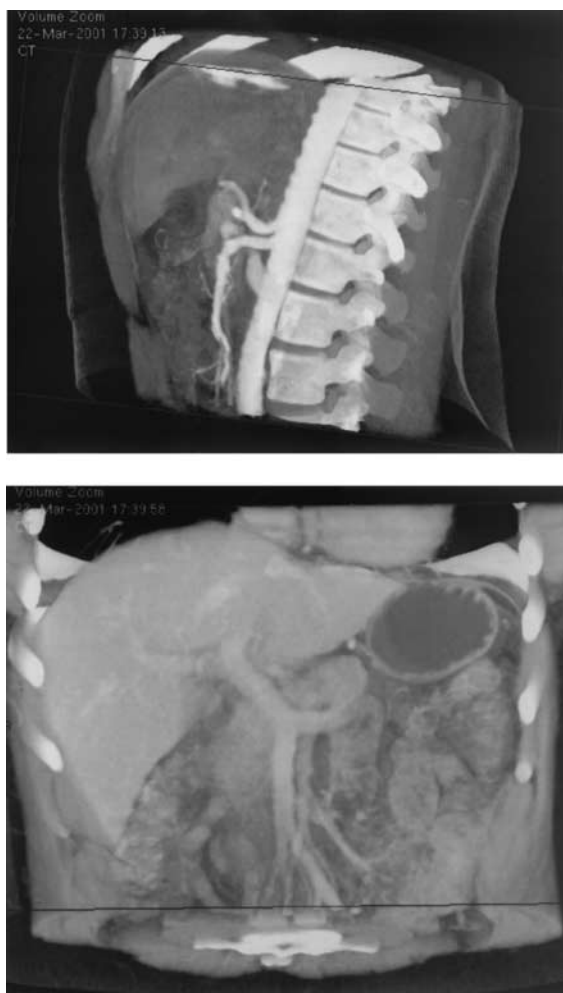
Multidetector CT images from patient with small cancer in head of pancreas. (Top) Sagittal 3-dimensional reconstruction shows normal aorta, celiac axis, and superior mesenteric artery. (Bottom) Coronal 3-dimensional reconstruction shows normal liver, gastric fundus, portal vein, as well as intact superior mesenteric artery and vein.
